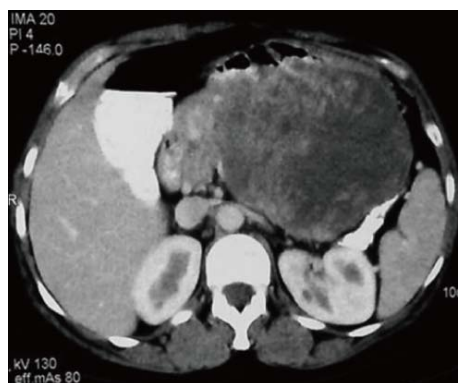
Axial computed tomography scan shows a well defined heterogeneous mass lesion arising from body and tail of pancreas with marked central necrosis which was proven as solid pseudo-papillary epithelial neoplasm after surgery.
